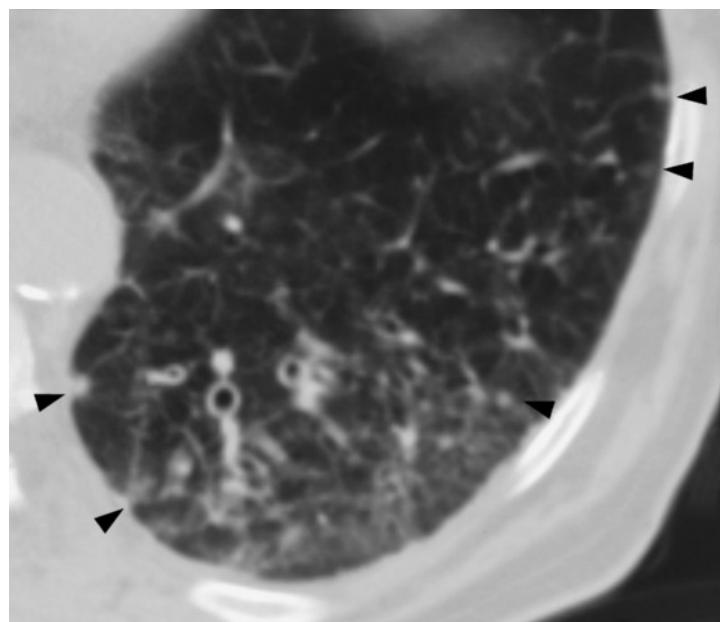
CT image of Fig. 2.22 (enlarged). CT findings include diffuse interstitial shadowing with several subpleural micronodules (black arrowheads). Severe bronchial wall thickening.
